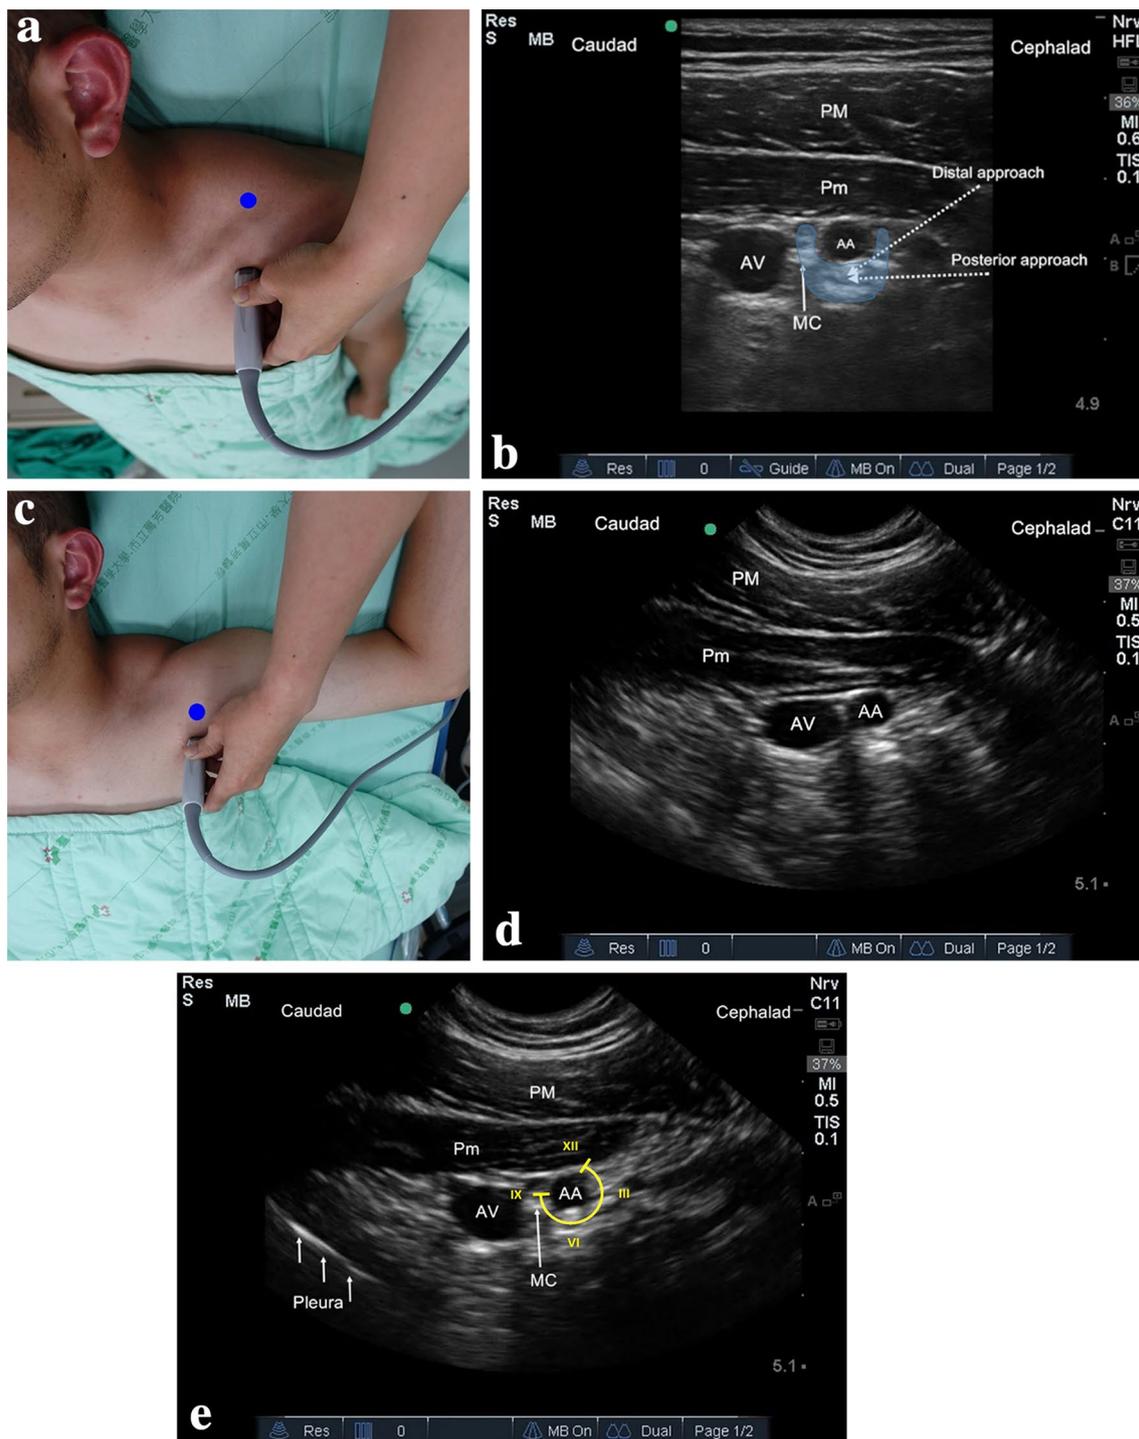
Ultrasound-guided distal approach for infraclavicular brachial plexus block. a Probe and patient positions for the posterior approach. The blue dot represents the puncture point at the supraclavicular fossa, penetrating below the clavicle with the needle in-plane. b Ultrasound image of the pectoralis minor space acquired using a linear probe. The pleura is usually not observed or is obscured at the corner of the venous side owing to the limited scanning range. With regard to the posterior approach, the needle shaft is perpendicular to the ultrasound beam and advanced caudally towards the same target site as the distal approach using a linear probe. The blue shaded area
